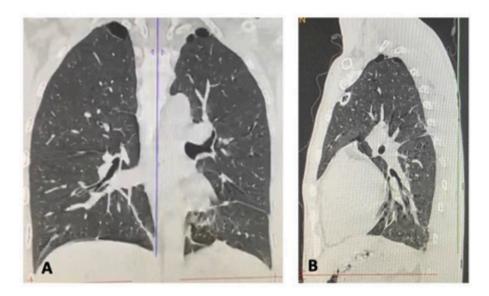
A. A high-resolution computed tomography (HRCT) taken three days after the chest X-ray (Fig. 1.) revealed paraseptal emphysema in the apical segment of the right upper lobe and the apicoposterior segment of the left upper lobe. B. These abnormalities are shown in the axial plane.
